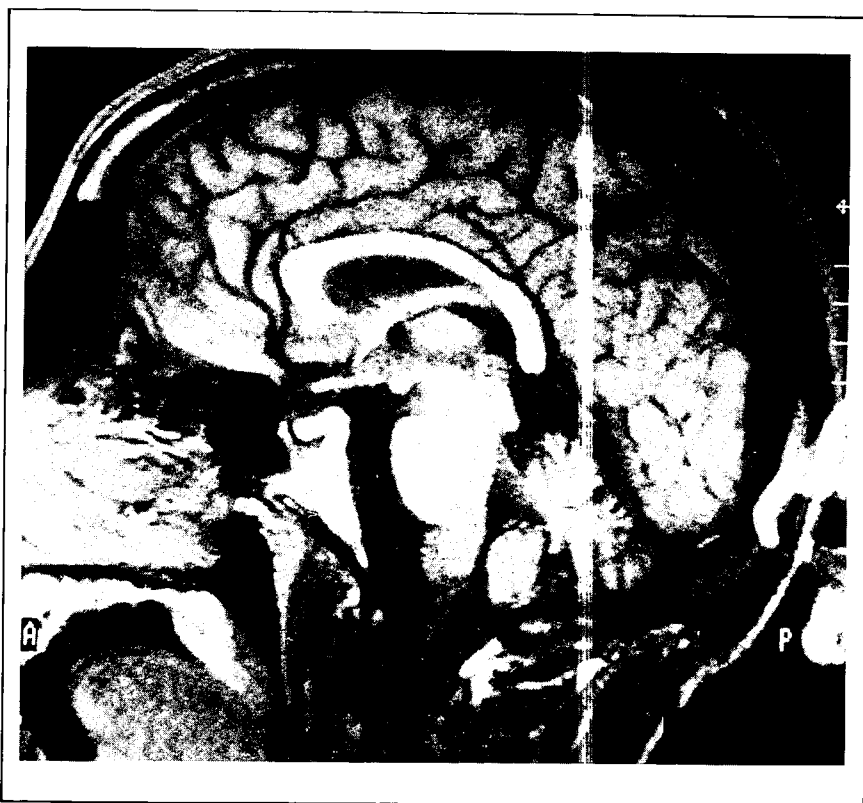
Sagittal T₁-weighted MRI demonstrating marked cerebellar atrophy
